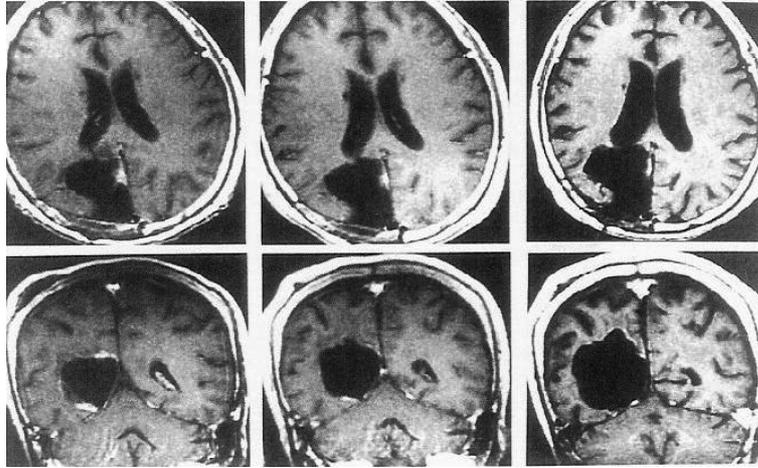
Serial computed tomography (CT) scan of a 66-year old female with right occipital glioblastoma (23). (a), image taken immediately prior to pritumumab therapy; (b) image taken 2.5 months after the start of pritumumab therapy; (c) image taken 1.5 years after the start of pritumumab therapy.
